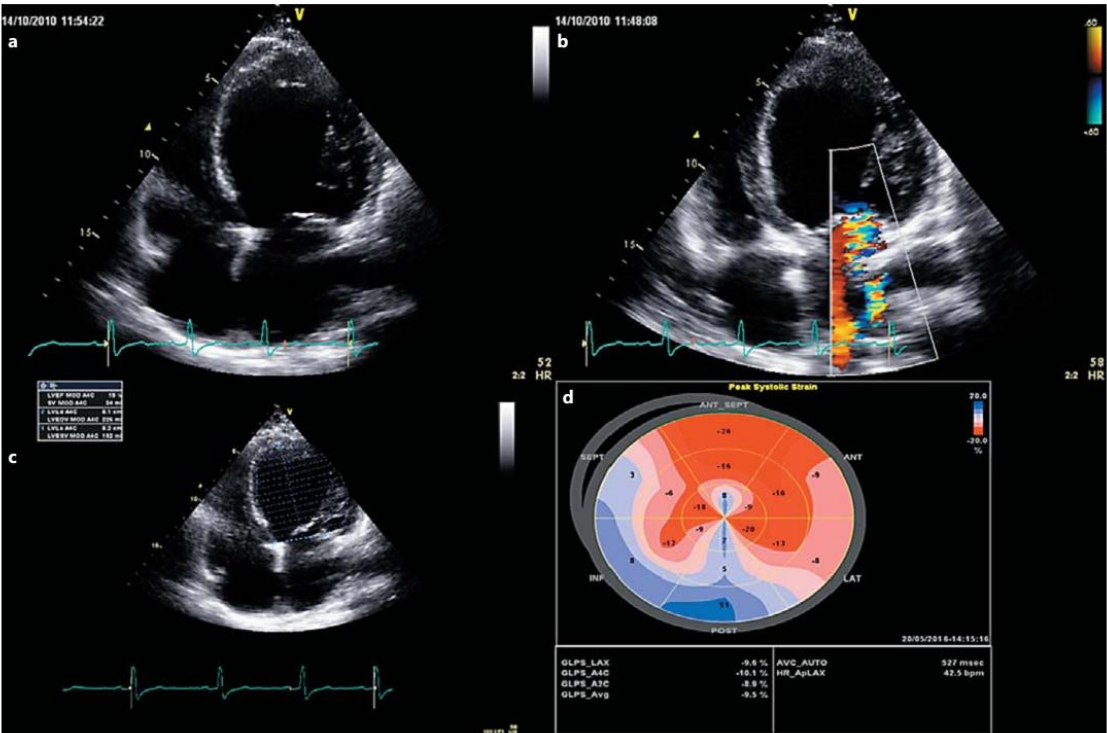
a Transthoracic echocardiogram, apical 4-chamber view, showing severe dilatation of the left ventricle. b Mitral valve Doppler colour flow showing mitral regurgitation grade III/IV. c Left ventricular ejection fraction of 15%, calculated by biplane Simpson's method. d Bull's eye plot of peak systolic strain, with a left ventricular circumferential strain rate of -9.6% and a longitudinal strain rate of -9.5%.
